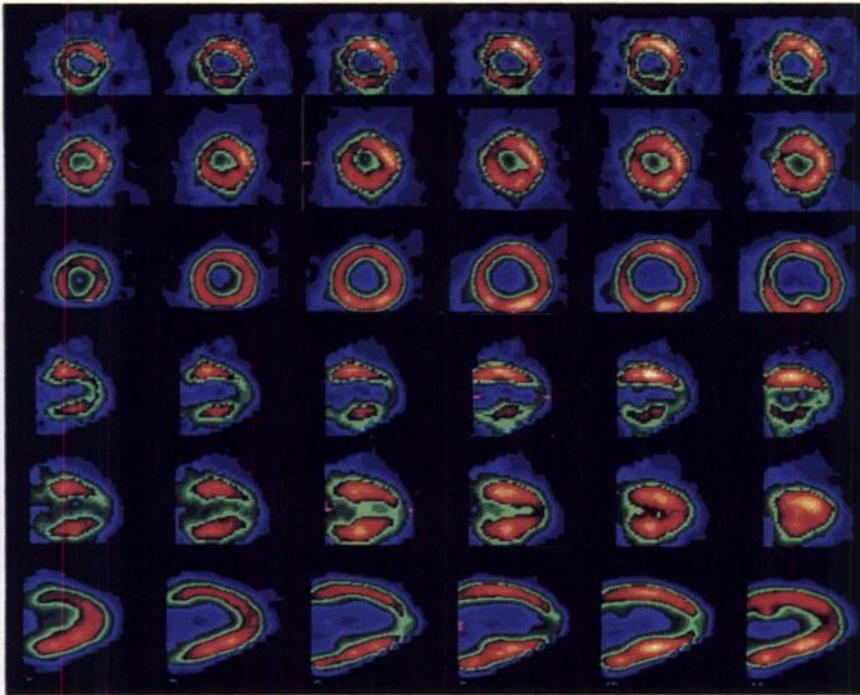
Rest thallium (1st and 4th rows), FDG-SPECT (2nd and 5th rows) and FDG-PET (3rd and 6th rows) short axis and vertical long axis images in a patient with a fixed apical thallium defect and inferior wall abnormalities. FDG-SPECT and FDG-PET show some increased uptake in these areas but with essentially little uptake in the apex. There is near equality between the FDG-PET and FDG-SPECT images.
